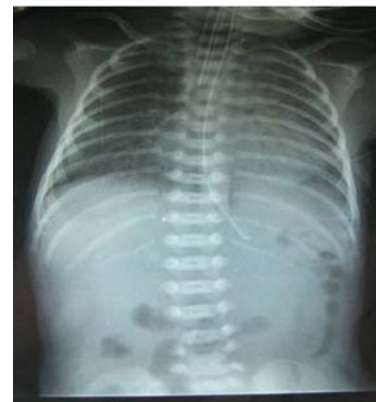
X-Ray chest-showing Clearance of lung fields after surfactant therapy
